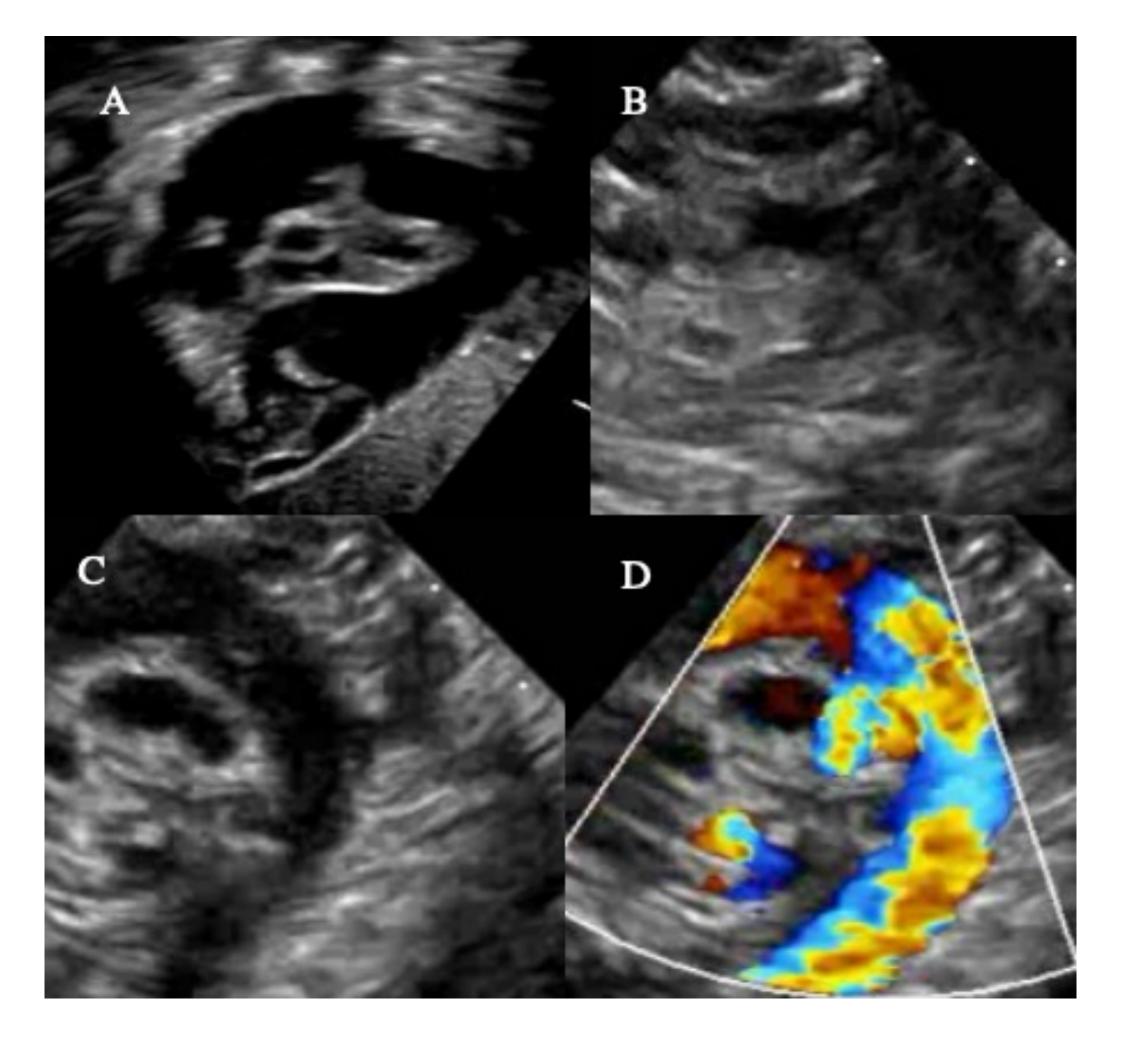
Transthoracic echo showing A. short axis view with dilated MPA, B. degraded suprasternal notch view of hypoplastic appearing transverse aortic arch, C. intact ductal arch with D. antegrade flow by color doppler
